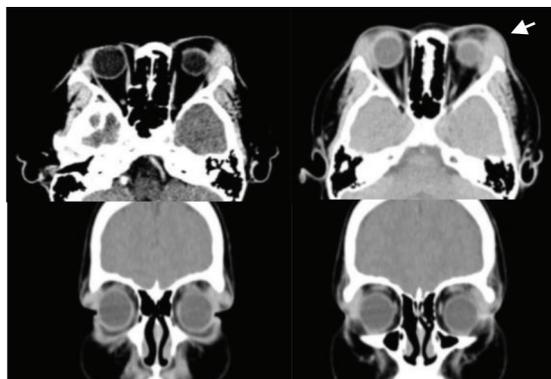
CT Scan readings indicate a sign of solid mass in left superior retropalpebral, in left lateral Bulbus oculi, sign of a mass from left Lacrimal Gland
